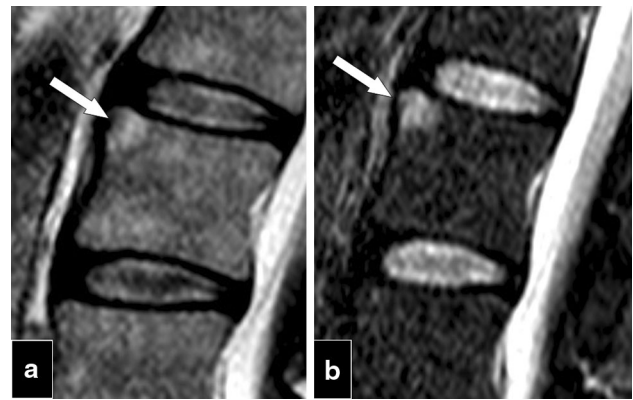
a, b 37-year-old man with primary ankylosing spondylitis. a Sagittal T2-weighted and b corresponding T2-weighted fat-suppressed magnetic resonance (MR) images show a focus of high signal intensity at the antero-superior corner of L1 body (*arrow* in a and b), which is called “shiny corner”. In this early stage conventional radiography usually appears normal
